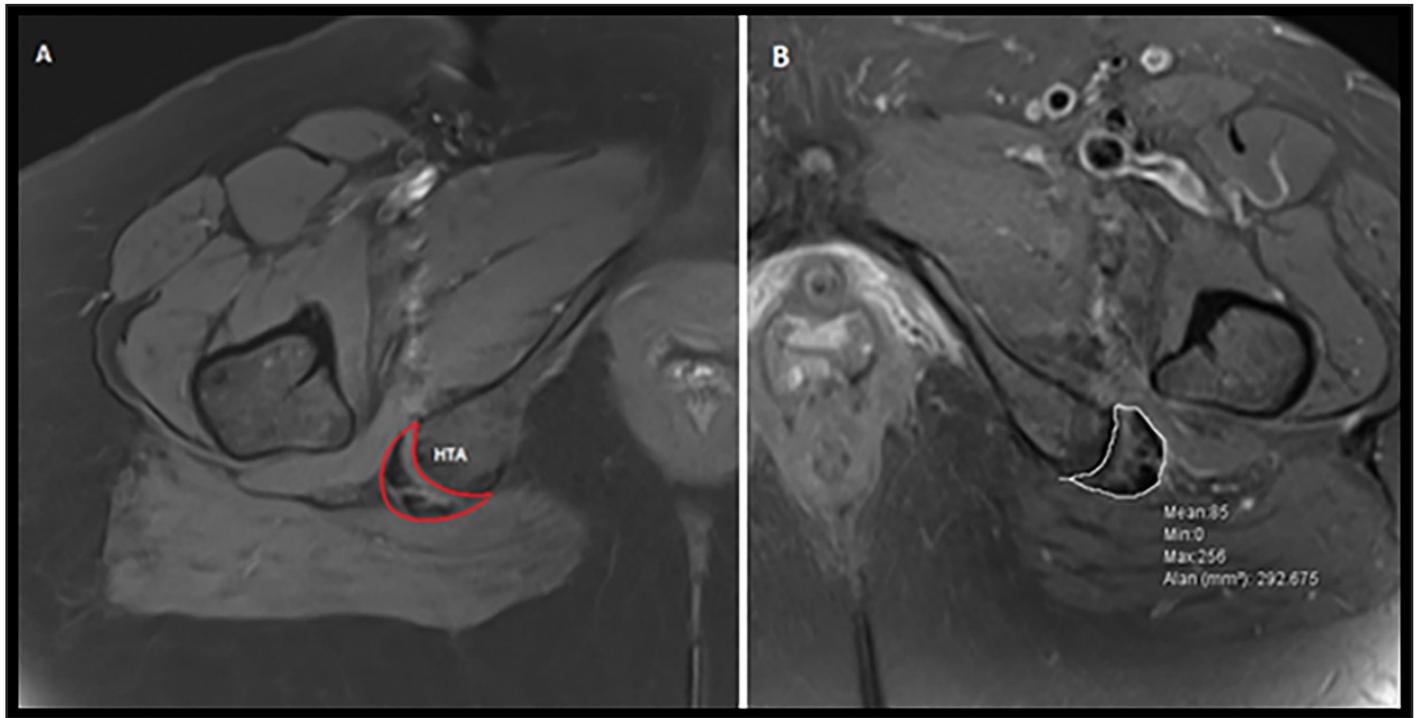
A Depiction of the hamstring tendon area (HTA) in the axial plane through magnetic resonance imaging (MRI), demarcated by red delineations and B Quantitative measurement of the HTA was derived from the MRI of a female patient, aged 59, who reported left groin pain. The patient demonstrated a negative result in the ischiofemoral impingement (IFI) test and a positive result in the long-step walking (LSW) test
